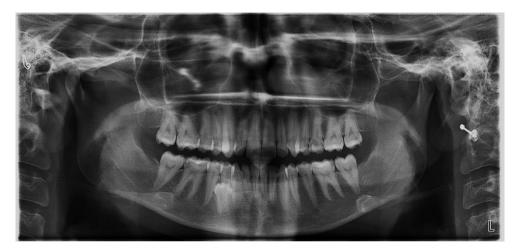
Panoramic radiograph showing styloid process type I
